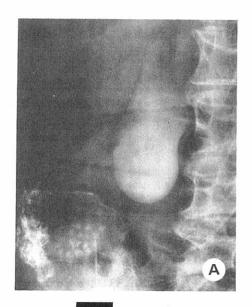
(MF 2006). A. Oral cholecystogram shows a calcification outside the projection of the gallbladder (arrow). B. Subcostal ultrasonography shows a bicameral gallbladder (g) and a calculus in its fundal chamber.
